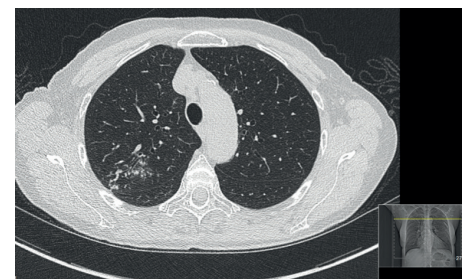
Computed tomography image of nodular bronchiectatic disease exhibiting nodules and dilated bronchioles.
